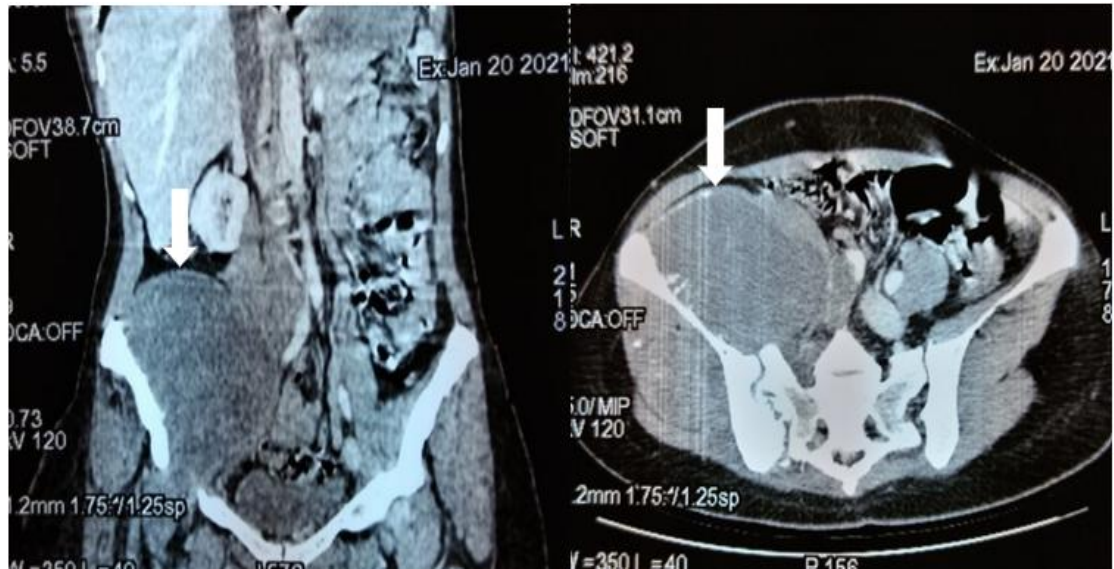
CT image showing a right coxo-pelvic mass with a speckled appearance of the iliac crest and extension to the sacroiliac, suggestive of Osteosarcoma.
